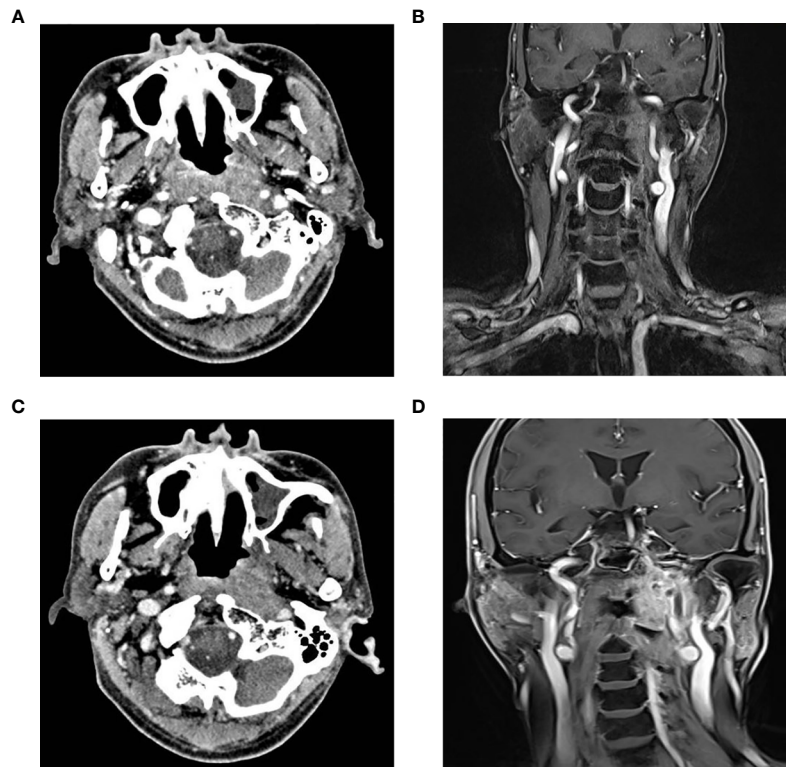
Imaging examination of ICA before and after embolization (A) Horizontal enhanced CT showed that the tumor partially wrapped the left ICA; (B) Coronal enhanced MRI exhibited that the tumor invaded the left pharyngeal recess, parapharyngeal space, the longus capitis, sphenoid body and skull base, and partially surrounded the left ICA; (C, D) Horizontal enhanced CT and coronal enhanced MRI showed the undeveloped cavernous, lacerum, petrous and cervical segments of the left ICA. CT, Computer Tomography; MRI, Magnetic resonance imaging; ICA, Internal carotid artery.
